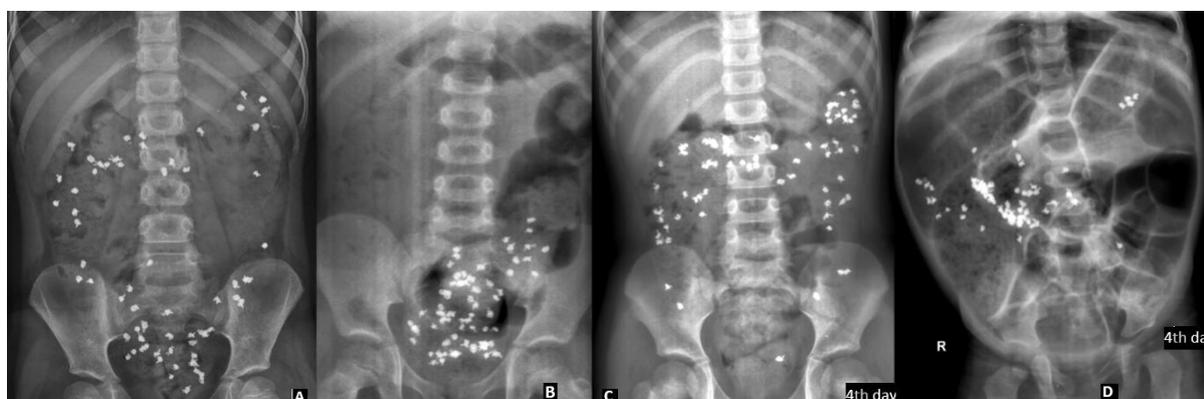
The 4th day radiographs of colon transit time from different patients; A) Normal pattern of CTT shows that most of markers have been defecated and there is non-segmental accumulation of markers. B) Abnormal rectosigmoid time shows accumulation of the markers in rectosigmoid area. C) Total colonic inertia is characterized by the accumulation of diffuse markers in the right and left intestines and their failure to reach the rectosigmoid area in 4th day. D) Only few markers have reached cecum in whole gut inertia cases.
